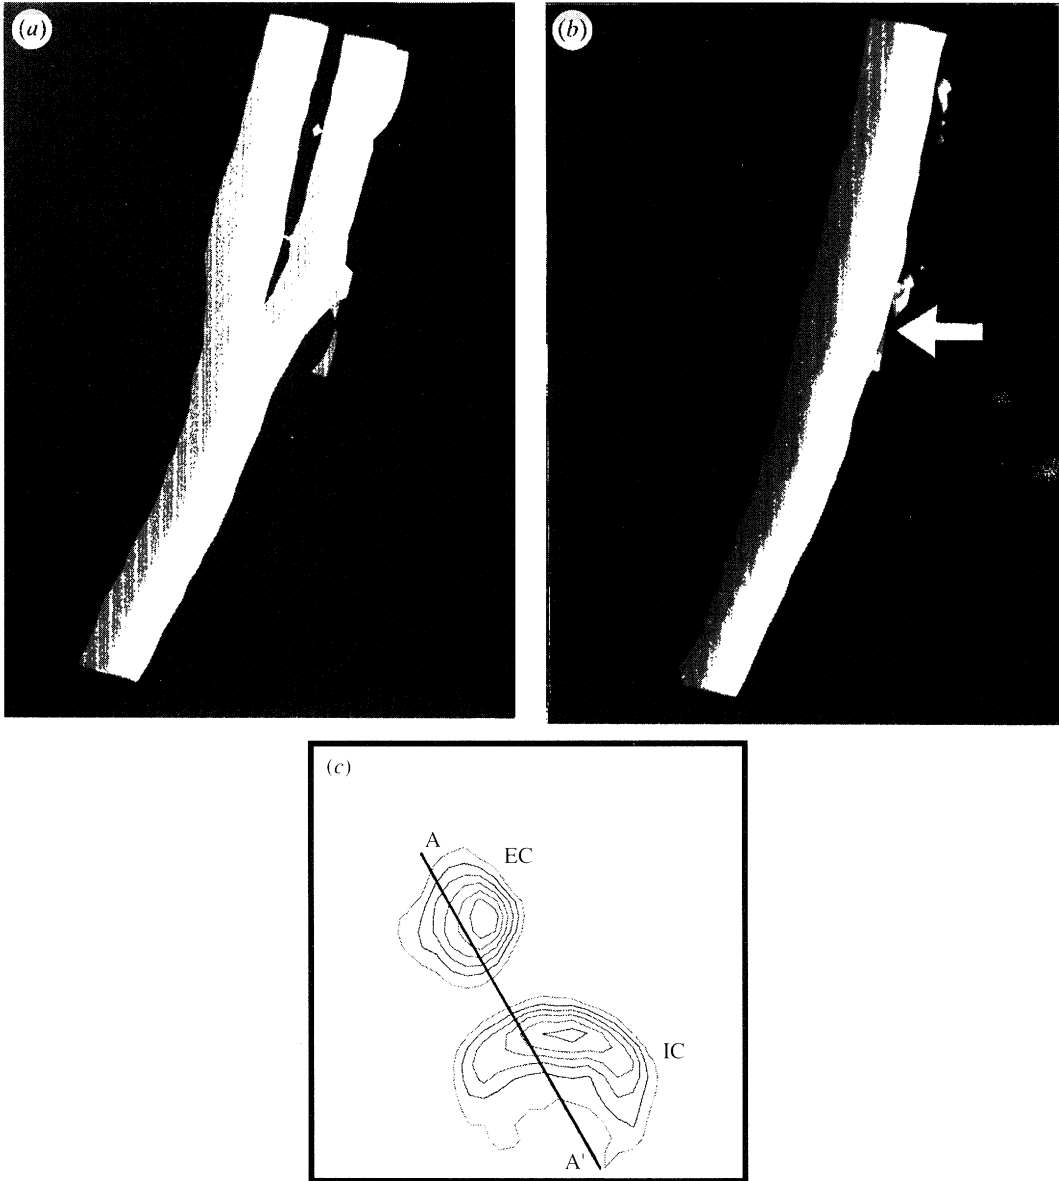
Reconstructed views showing (a) coronal and (b) sagittal MRI projections of the bifurcation of the left common carotid artery of a healthy human subject. Arrows denote the location of bifurcation. The sagittal projection shows curvature in the 'plane' of bifurcation, which renders the bifurcation non-planar. (Artefacts are seen, caused by the reconstruction technique.) Shown in (c) are axial velocity contour plots for internal (IC) and external (EC) carotid arteries, acquired 1 cm downstream of the bifurcation. The axial velocity distribution is seen to be rotated out of the 'plane' of bifurcation (A - A') and to be asymmetric.
